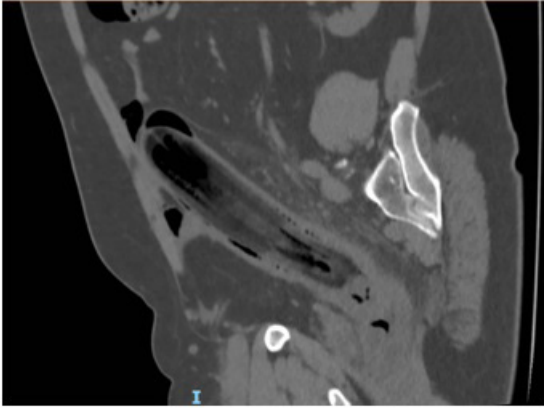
CT scan of the abdomen showing the presence of a 20 cm long foreign body in the rectum
